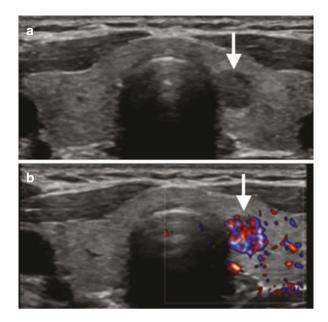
EU-TIRADS 5 nodule. A taller-than-wide markedly hypoechoic nodule with irregular margins is shown (arrows) in the left thyroid lobe on grayscale (a) and Doppler (b) US scans. This nodule was investigated with FNAB and classified as malignant (TIR 5)
